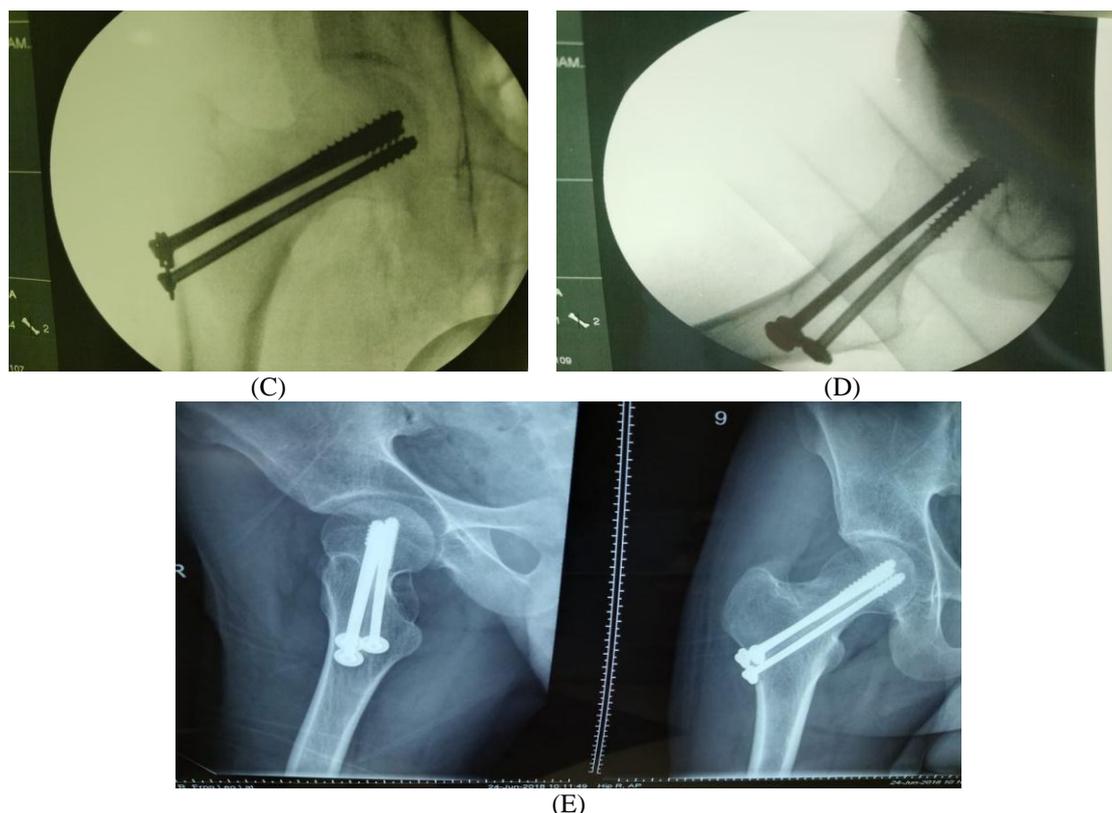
(A, B) Pre-operative X-rays, C,D) Post-operative X-rays, E, F) Follow up X-rays.
